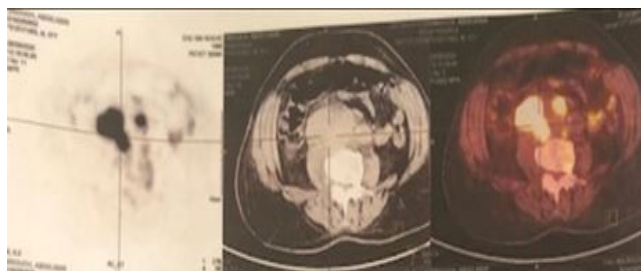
Choline PET-Scan Showed Hyper Metabolic Para-Aortic Lymph Nodes (SUV_{max} 10.02).
